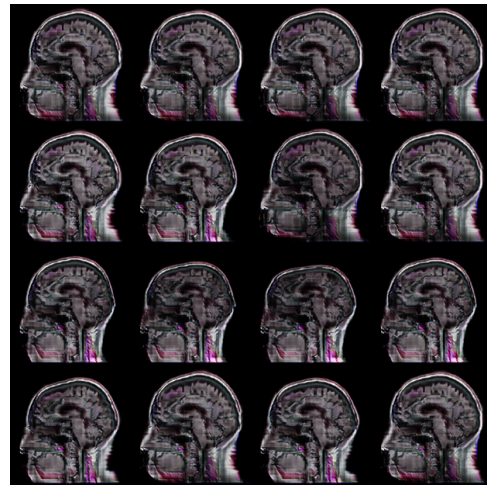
Results CGDCGAN trained on a conditioned image of MR image with epoch running upto 50000. This is result is from 6th month data.
